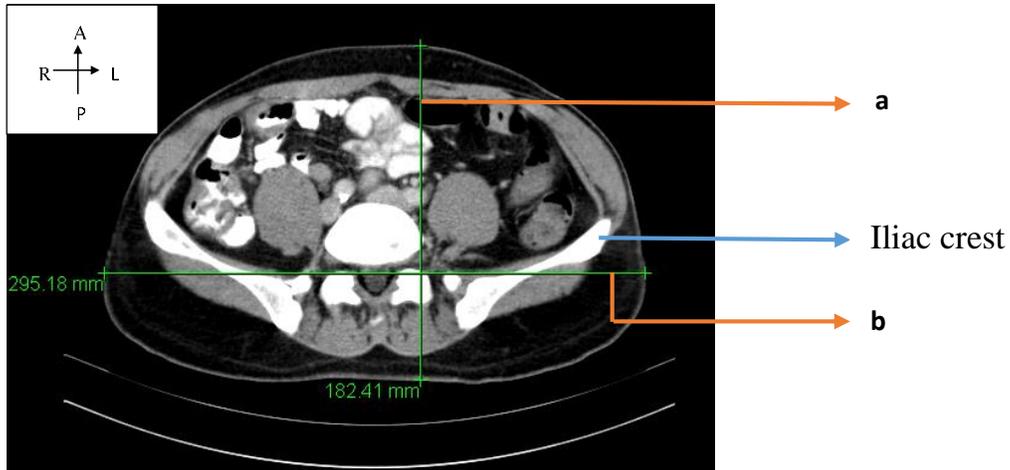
CT Abdomen- Measurements of Tomographic Image - At the Level of Iliac Crest (Level A2)
